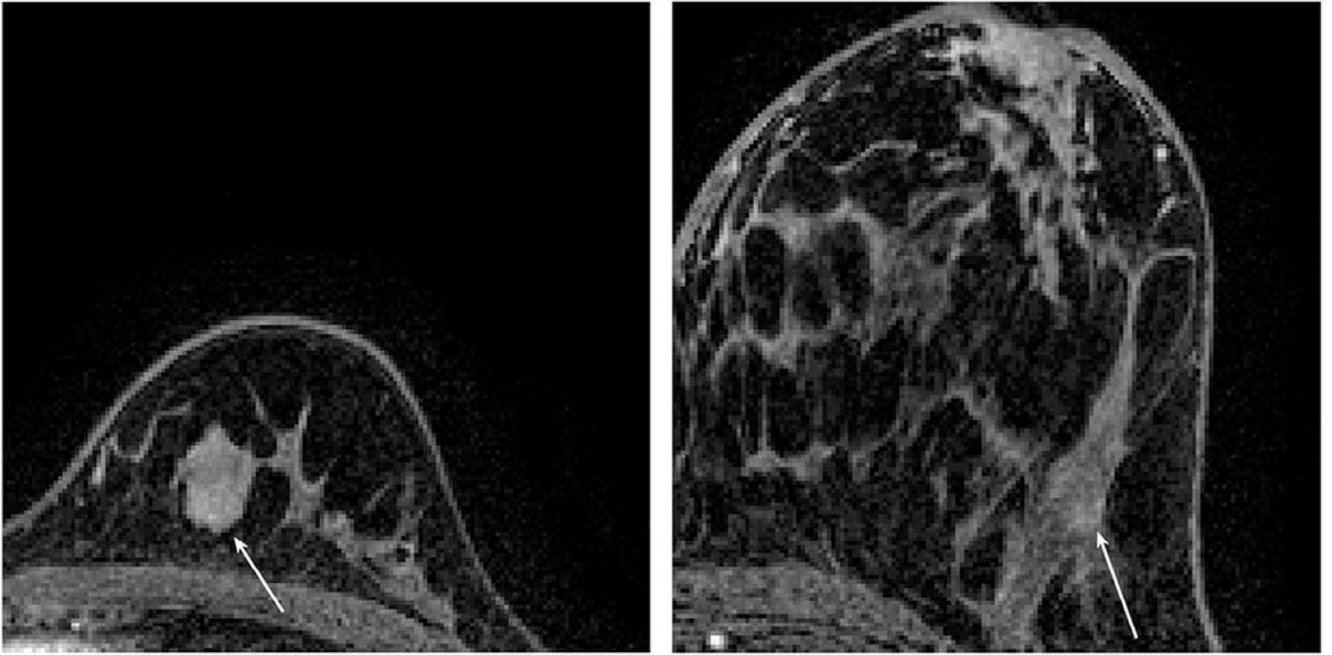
Postcontrast dynamic contrast-enhanced magnetic resonance images of a benign lesion (*left*) and a luminal A cancer (*right*). The position of the lesion and the cancer is indicated by a *white arrow*. Each image was acquired at 1.5T and is $125 \times 125 \text{ mm}^2$ in size, cropped from the full image. Slice thickness for each image was 2 mm. The maximum linear size for the benign lesion is 20.1 mm and the irregularity is 0.50. The maximum linear size for the luminal A cancer is 13.4 mm and the irregularity is 0.78.
